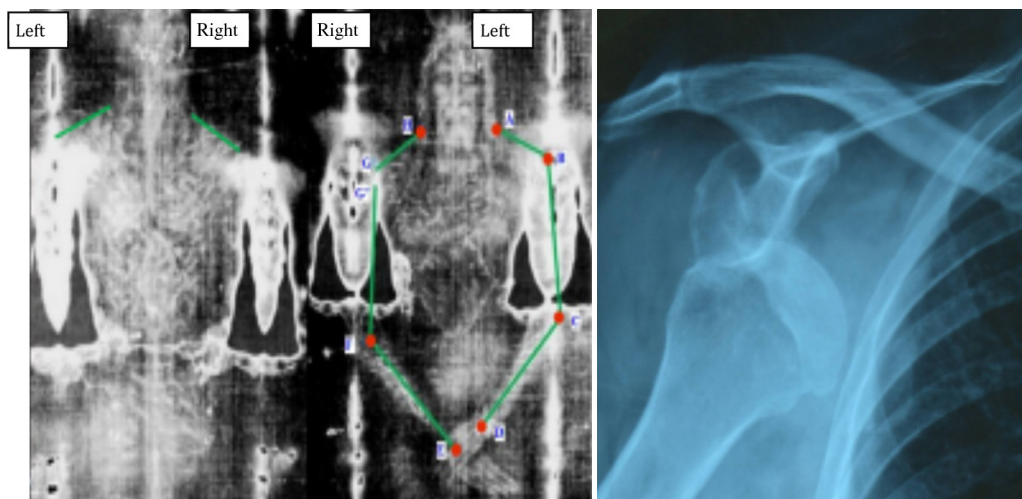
On the left: position of shoulder and arms on the frontal and dorsal body image of the TS with positions of the pivotal points measured in Table 1. On the right: radiography of an underglenoidal dislocation.
